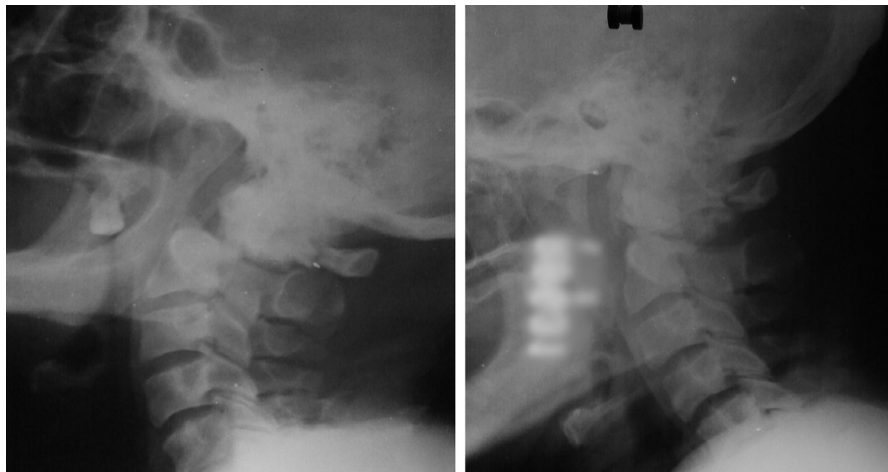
Preoperative X-rays of craniocervical junction (CVJ) showing (Left) worsening of posterior atlantoaxial dislocation (AAD) after application of traction in extension (Right). Traction in flexion reduced the dislocation.
